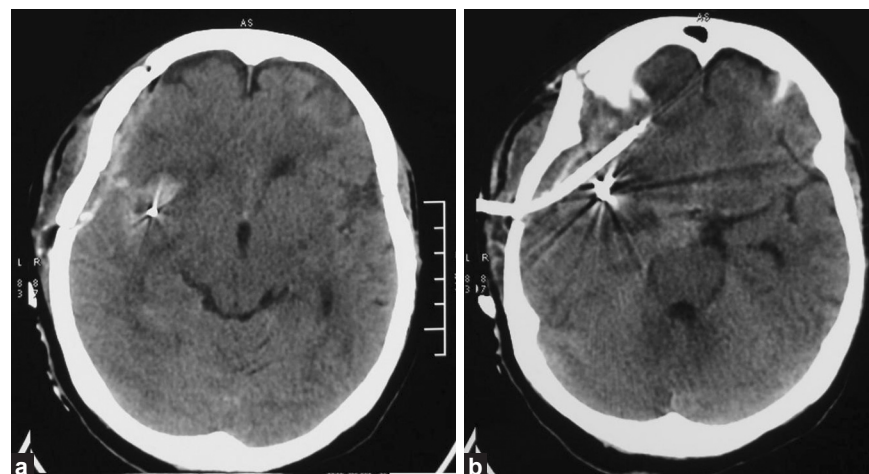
(a) CT brain scan showing hematoma and subarachnoid blood in right ambient cistern, immediately after clipping (b) Seventy two hours post-irrigation CT brain scan showing clearance of subarachnoid blood, FLUX catheter *in situ*
